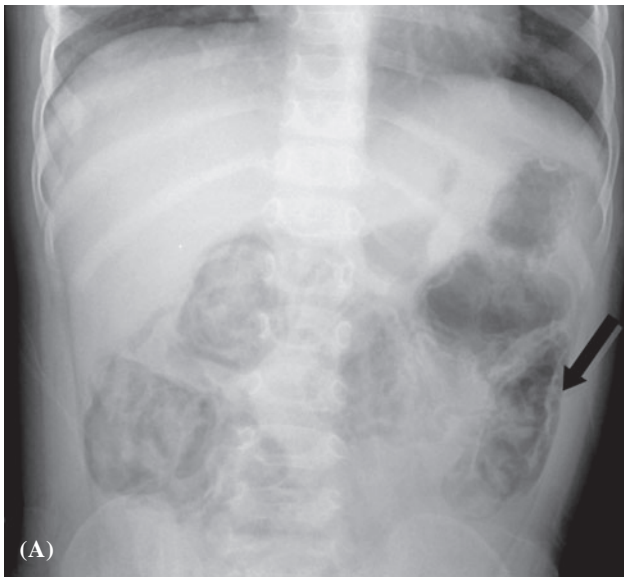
Clinical imaging/photographs of sibling 1. (A) Abdominal X-ray showing pneumatosis intestinalis. (B) Abdominal CT scan with contrast showing pneumatosis intestinalis. Black arrows (↑) indicating intestines with intramural gas. White arrow (↑) indicating lumen of intestine. (C) Chest radiograph showing interstitial pneumonitis due to *Mycoplasma pneumoniae*. Note the absence of thymus shadow. (D) Tea-colour plasma product obtained from plasmapheresis.
